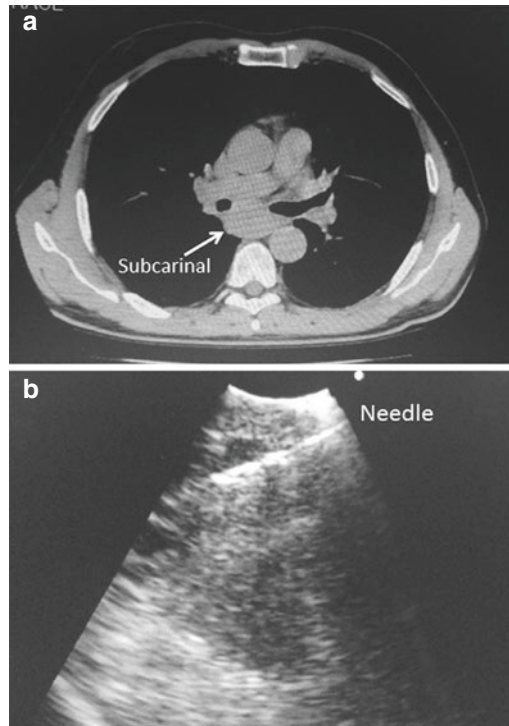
A 71-year-old man with a squamous cell carcinoma of the right lower lobe presented an enlargement of the subcarinal lymph node (station 7) on computed tomography scan (a). EBUS-TBNA (b) resulted to be positive for metastasis. Photo courtesy of Mario Polverino, MD, and Carlo Santoriello, MD of Pneumology Unit of Scafati Hospital, Scafati, Italy
